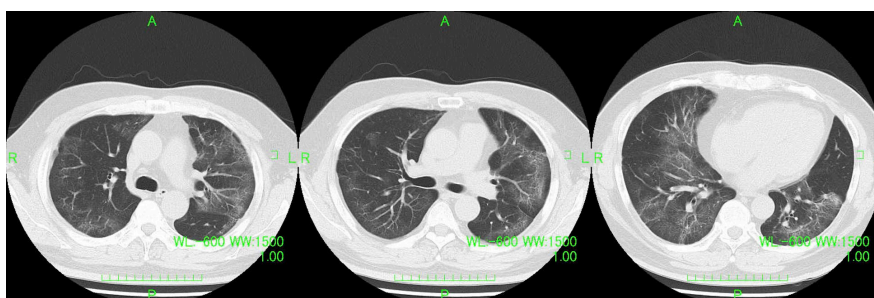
A CT of the patient's chest showed that the ground glass shadow with dorsal peripheral dominance.
